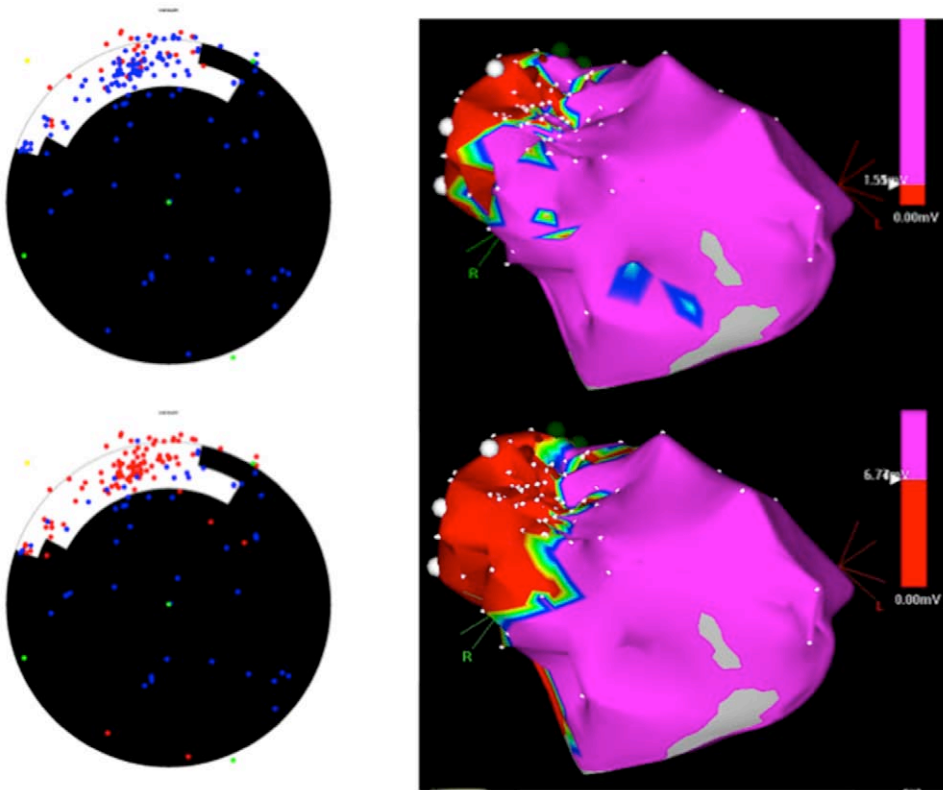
Left, Polar view of the delayed-enhanced MRI image of the same patient shown in Figure 1. Bipolar electroanatomical map (top; blue points, voltage ≥ 1.5 mV; red points, voltage < 1.5 mV as it projects on the polar map). Unipolar endocardial electroanatomical mapping points projecting on the polar map (bottom; blue points, voltage ≥ 6.8 mV; red points, voltage < 6.8 mV). Right, Corresponding bipolar (top) map with a cut-off voltage of 1.55 mV and the corresponding unipolar (bottom) map with a cut-off voltage of 6.8 mV.
